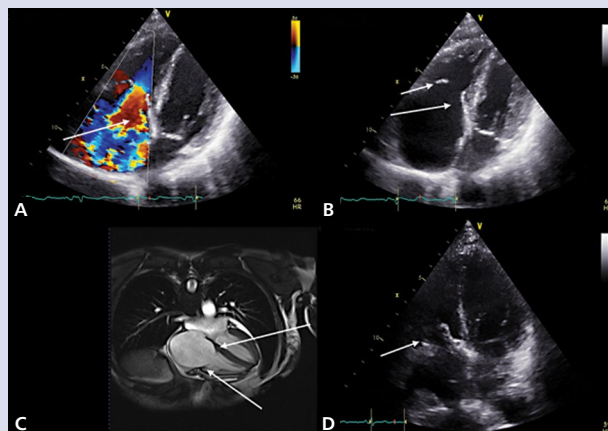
Severe tricuspid regurgitation in carcinoid heart disease before and after cardiosurgery; A. Transthoracic echocardiography (TTE), modified four-chamber view: arrow—huge tricuspid regurgitation; B. TTE, four-chamber view: arrows — fibrosis and calcification of tricuspid valve leaflets; C. Cardiac magnetic resonance imaging: arrows — poor coaptation of the leaflets of the tricuspid valve, and its high-grade insufficiency with huge enlargement of the right atrium; D. TTE after surgery, four-chamber view: arrow — bioprosthesis in tricuspid position
